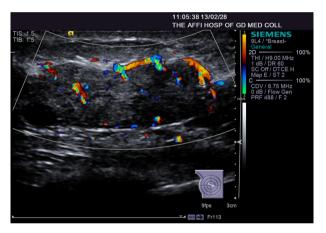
Ultrasound image of increased vascularity around and within the mass.
